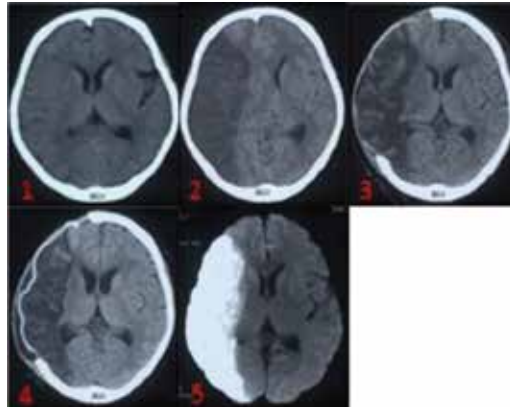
Stroke evolution followed with imagery, CT, and MRI. Non-contrast CT scan images at hour 2 (image 1), day 2 (image 2), week 2 (image 3), and week 3 (image 4) of stroke event. Non-contrast MRI at hour 12 of stroke event (image 5). CT scan findings in ischemic CVAs: *Note: These principles do not apply to small lacunar infarcts, or hemorrhagic CVAs.*
